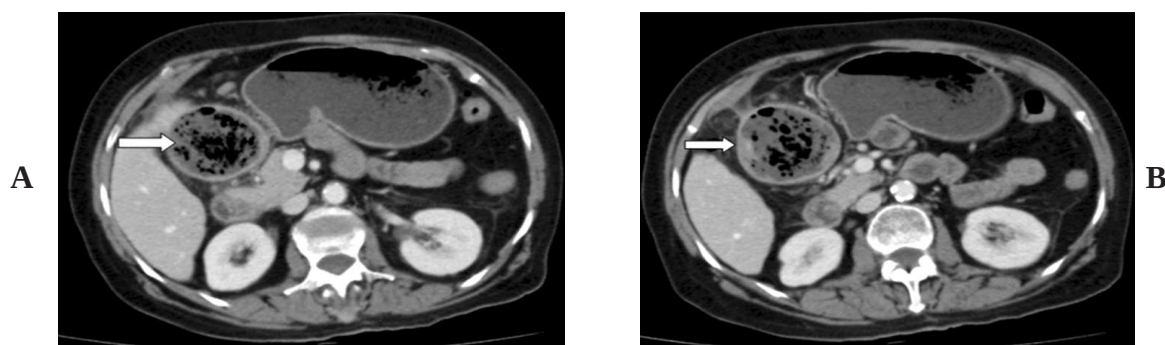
CT scan of abdomen showing (A) a large thick walled cavity approximately 90 mm with fluid and gas contents (B) pushing the duodenum and the distal stomach.
